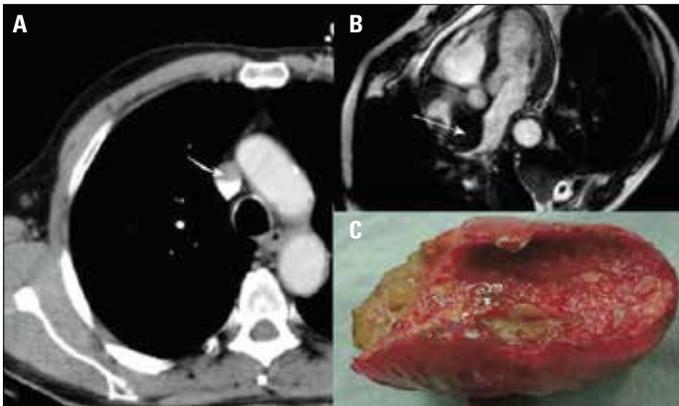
(A) The computed tomography image of the mass narrowing the ostium of superior vena cava. (B) Cardiac MR showing a right atrial mass. (C) Macroscopic view showing a cardiac mass
